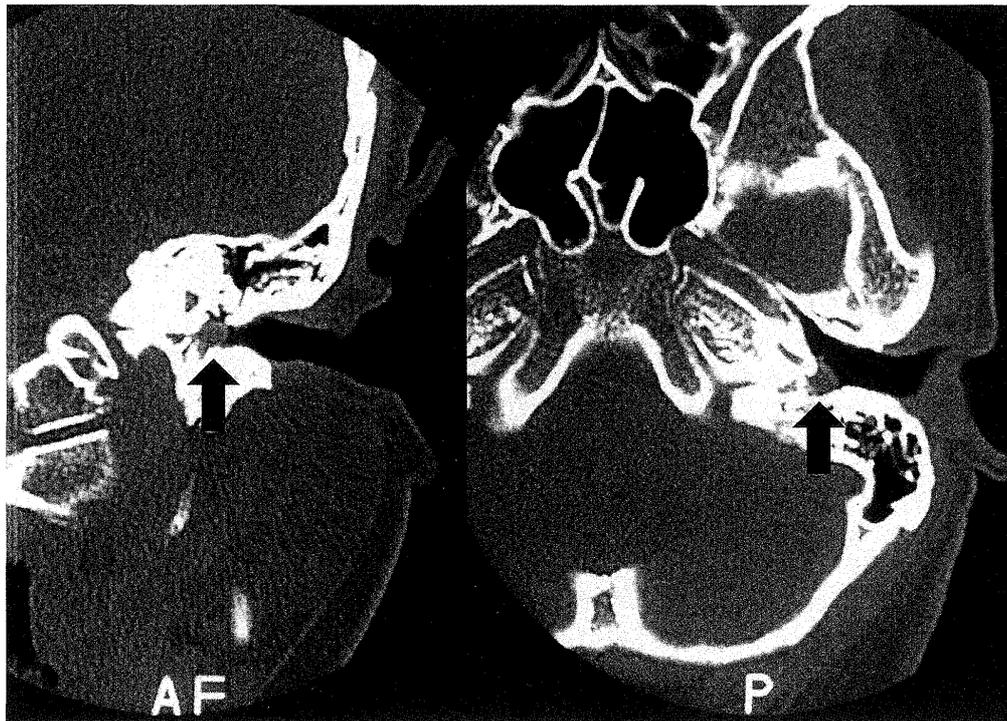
CT images : coronal view (left) and horizontal view (right) revealed a mass of soft tissue density in the left hypotympanum (arrow). No evidence of bone destruction or erosion was visible adjacent to this lesion.
